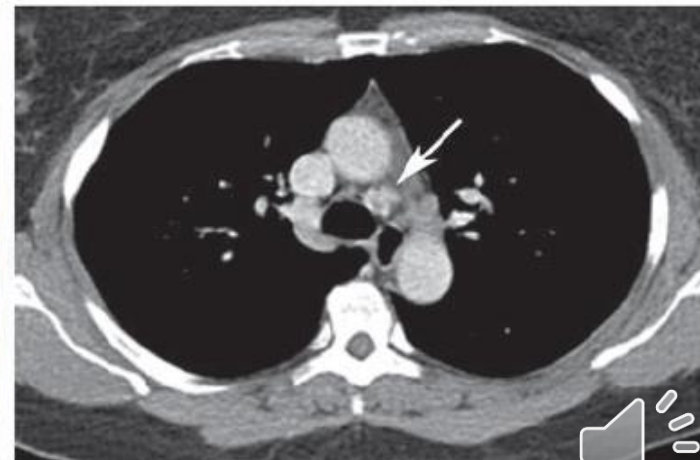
Mediastinal parathyroid adenoma in a 52-year-old woman with persistent primary hyperparathyroidism after three-gland excision. (a, b) Coronal (a) and axial (b) fused early-phase SPECT/CT images depict a paratracheal mass (arrow in a) at the left tracheobronchial angle. (c) Axial CT image subsequently obtained with intravenous contrast material depicts an enhancing 12 × 13-mm left paratracheal mass (arrow) suggestive of a parathyroid adenoma. A 1.3-g adenoma was resected with a median sternotomy.
